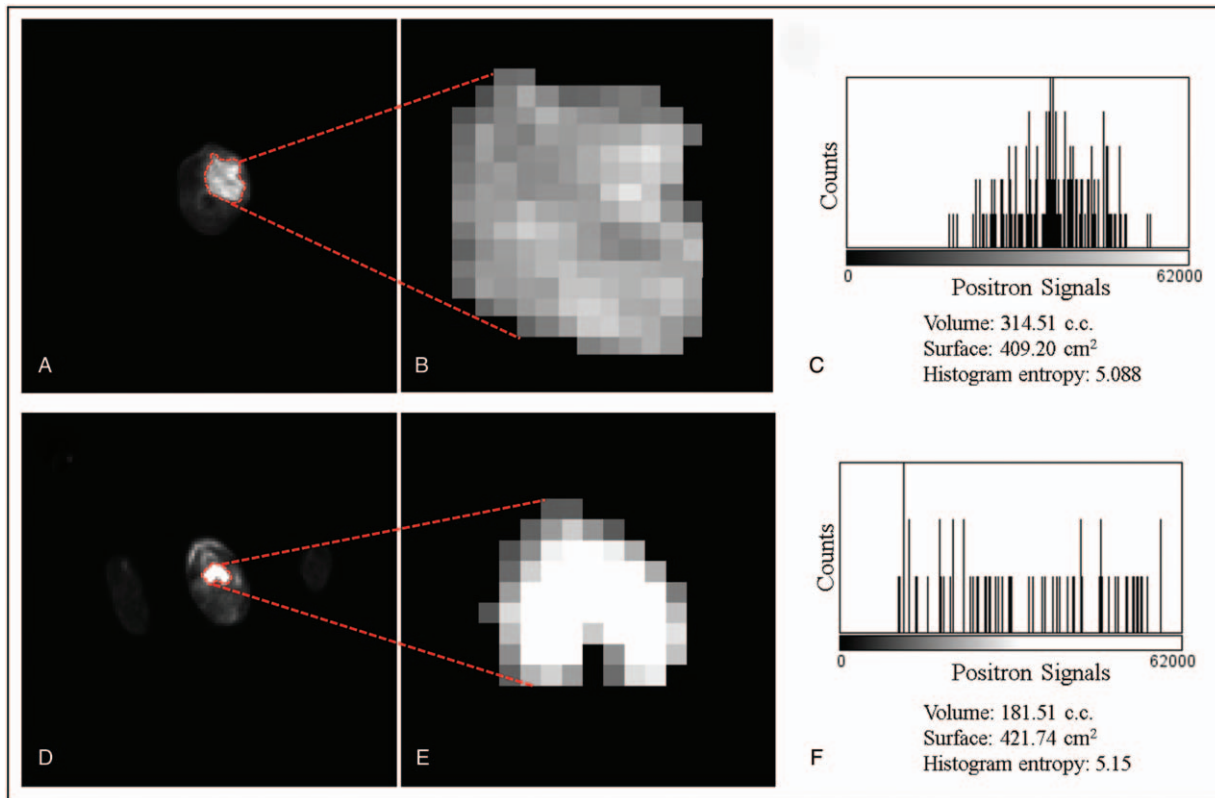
Two slices of PET which show the FDG uptake from 2 patients with oropharynx (A–C) and hypopharynx (D–F) tumors, respectively. A and D show the original PET images with the delineation (red dashed lines). B and E show the zoomed images of the segmented tumor. C and F show the histogram of the positron signal versus the photon counting. FDG = fluorodeoxyglucose, PET = positron emission tomography.
